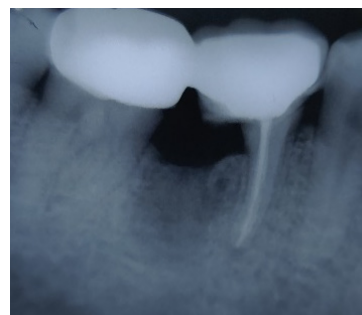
Post-cementation radiograph
